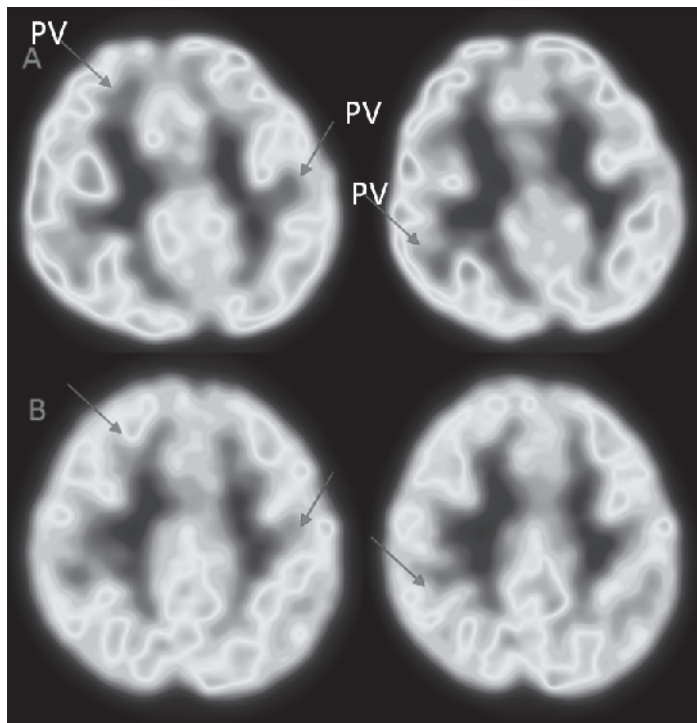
Comparative FDG-PET CT Brain demonstrates (A) Dilation in the lateral ventricle before cellular transplantation (b) Significant improvement observed in periventricular areas -PV after cellular transplantation indicated by arrows.
